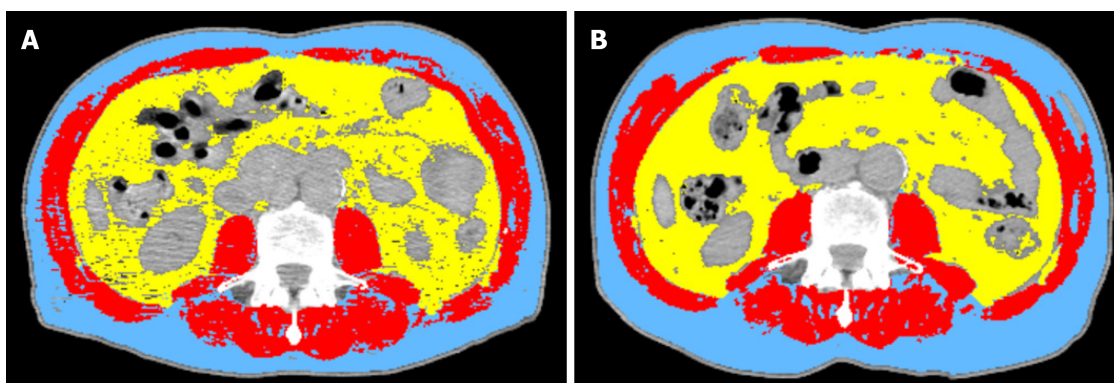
Radiologic image showing a comparison of body composition at diagnosis (A) and post neo-adjuvant (B) chemotherapy (two computed tomography scans of the third lumbar vertebra skeletal mass) for the same patient. Red: Muscle; Yellow: Visceral fat; Blue: Subcutaneous fat.
